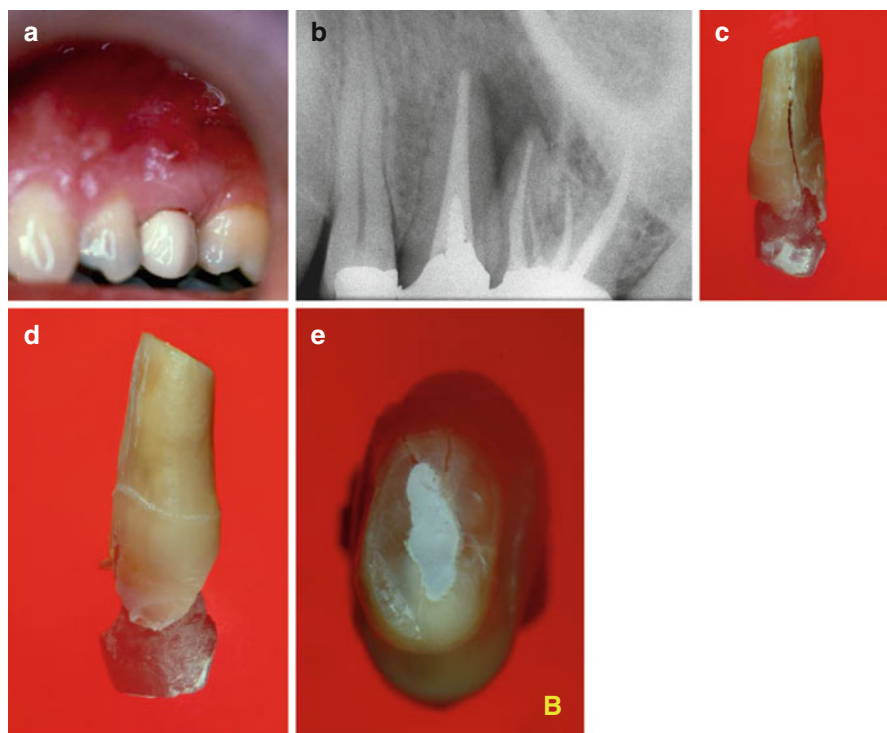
(a–e) A patient arrived at the dental office with a complaint of “draining pus from the gum” in the upper jaw. Clinical examination revealed a veneer crown in the second premolar that was endodontically treated and restored at the same time with the maxillary molar adjacent to it (a). A highly located sinus tract was noted, but the probing numbers were between normal limits. Endodontic treatment appeared adequate in the radiograph (b), but a large radiolucent area can be seen laterally in the distal aspect of the premolar tooth involving the mesiobuccal root of the maxillary molar. Poor outcome of the endodontic treatment either in the maxillary premolar (chronic apical abscess) or the mesiobuccal root of the molar led to the treatment plan of endodontic surgery either in the premolar or the mesiobuccal root or both. Endodontic surgery was performed in the maxillary premolar with IRM as a retrograde filling material. At 12 months post-op, the patient returned with an acute abscess, and the premolar was extracted. A VRF was noted in the buccal aspect (c), but it was of the incomplete type since it was not seen in the buccal aspect (d). In the apical view (e), the incomplete VRF can be seen in the palatal aspect but not in the buccal one. Most likely, the incomplete VRF on the palatal aspect was not noticed during surgery
